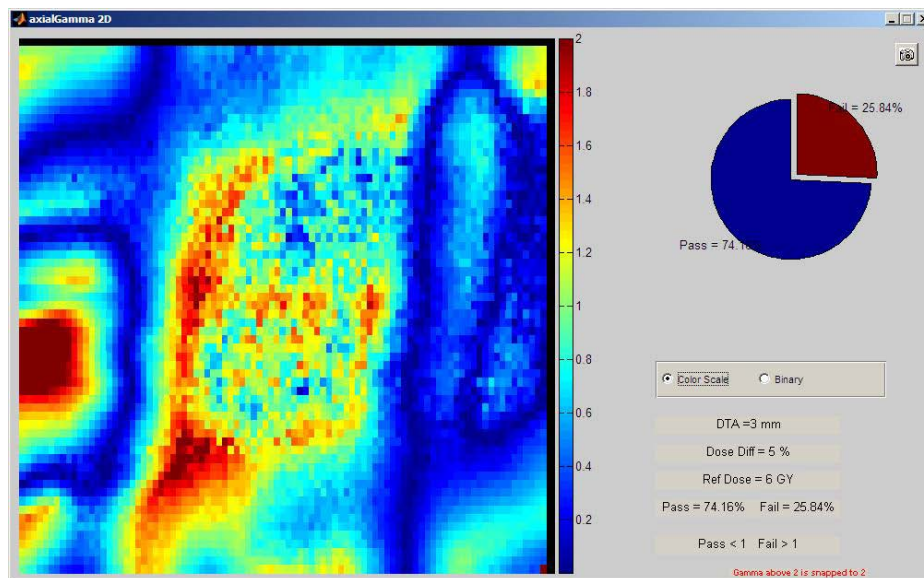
Plan 1b Trial 2 Axial Gamma Analysis with PVC Shell contoured and CT Number set to match Eclipse Calibration Curve
